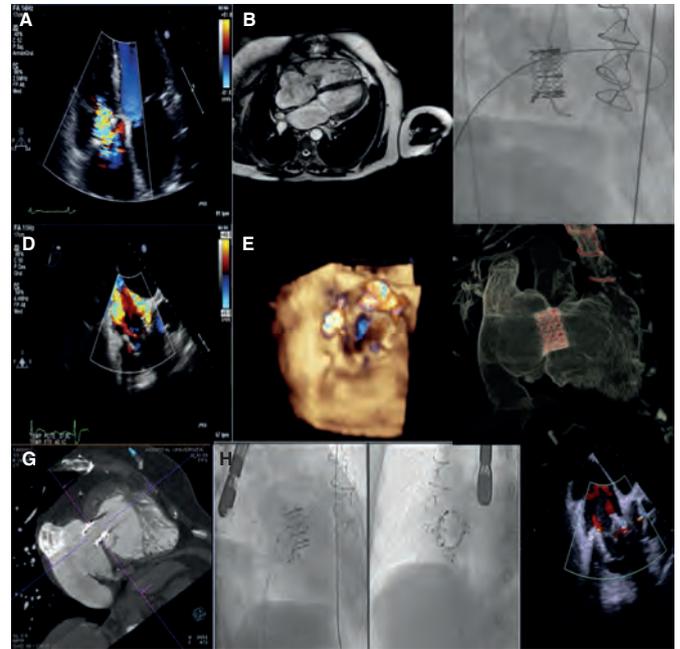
A: transthoracic echocardiogram showing severe tricuspid regurgitation. B: CT scan prior to valve implantation. C: implantation of the Edwards bioprosthetic valve using the Safari guidewire. D and E: severe residual tricuspid regurgitation due to 2 paravalvular leaks. F and G: CT scan prior to the closure of paravalvular leaks. H: closure of posterior inferior leak. I: closure of septal leak. J: final outcome without significant tricuspid regurgitation.
